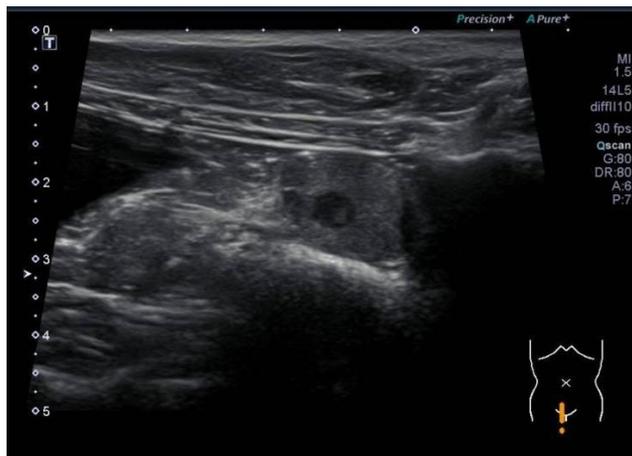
Ultrasound sagittal view of the prostate
